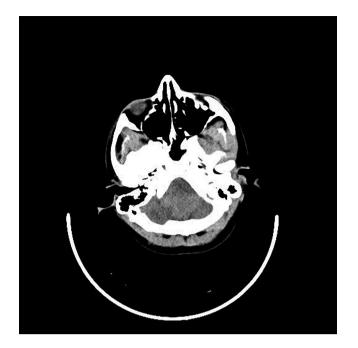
CT scan demonstrating a well-defined solid lesion at the infratentorial posterior fossa, located at the extramedullary region near the foramen magnum. The image reveals features suggestive of an infratentorial posterior fossa neoplastic lesion with a defined extent and associated adjacent mass effect.
